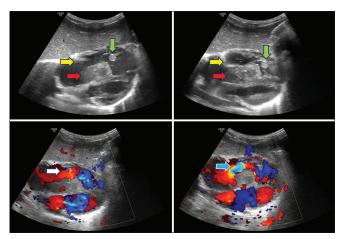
Echocardiography shows an echogenic mass along the septal wall of the right ventricle involving the septal leaflet of the tricuspid valve (red arrow). Another similar lesion is in the free wall of the right ventricle (green arrow). A free leaflet of the tricuspid valve is seen (yellow arrow). On color Doppler, forward flow is seen on atrial systole through the tricuspid valve (white arrow) and tricuspid regurgitation is seen as aliasing on the ventricular systole phase (blue arrow)
